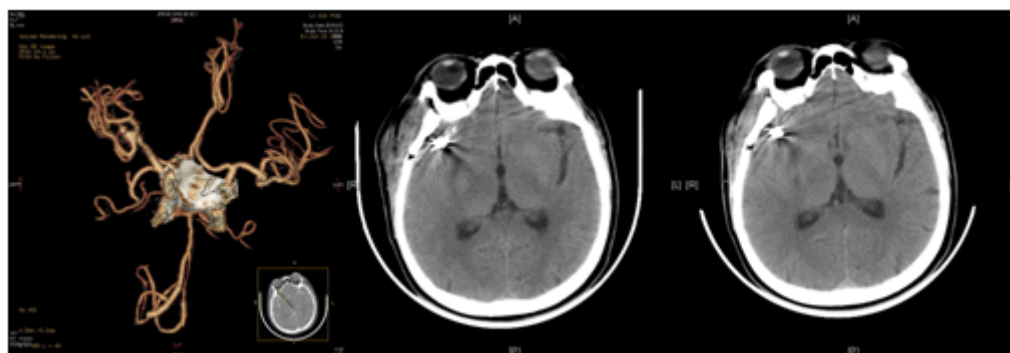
A. Computed tomographic angiography (CTA) demonstrating bilateral saccular aneurysms on each side of middle cerebral artery. B. Computed tomography (CT) on the third day after surgery demonstrating no sign of ischemia. C. CT showing cerebral ischemia in the region of the right basal nuclei.
